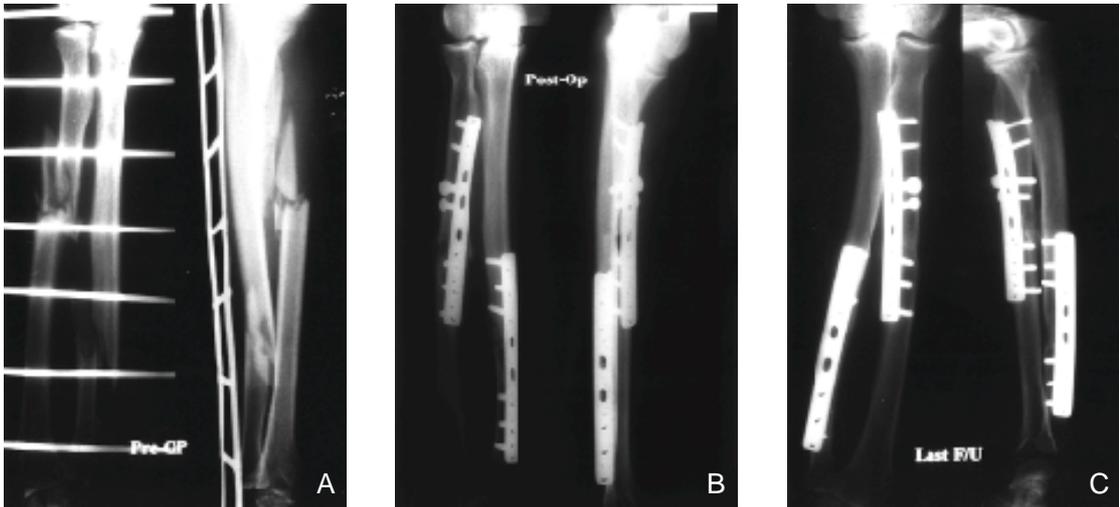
Both forearm initial AP and lateral radiograph of fifty-three years old male patient after traffic accident.
